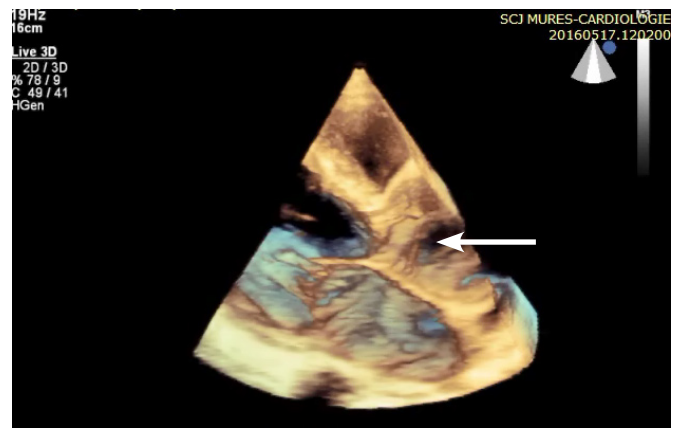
3D transthoracic echocardiography (live 3D) – parasternal long axis view: visualisation of the dissection membrane in the aortic lumen (arrow)
